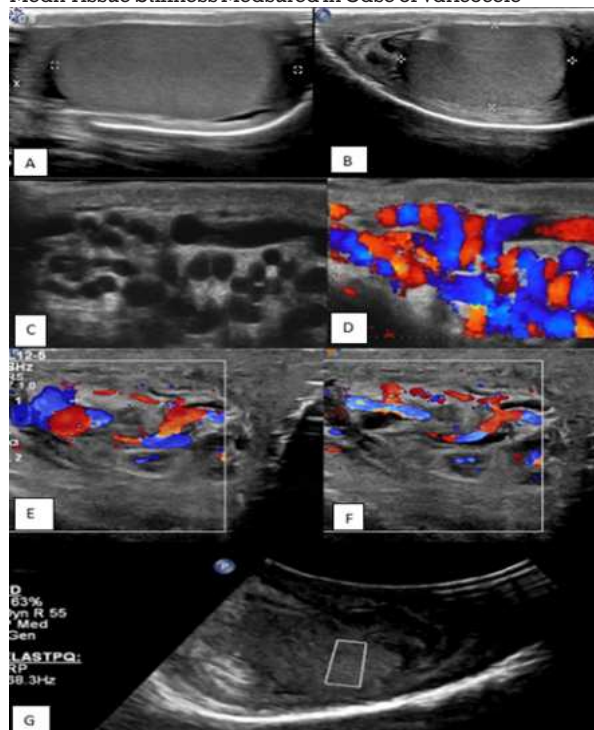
Ultrasound Examination of Testis Depicting Varicocele and Elastography
